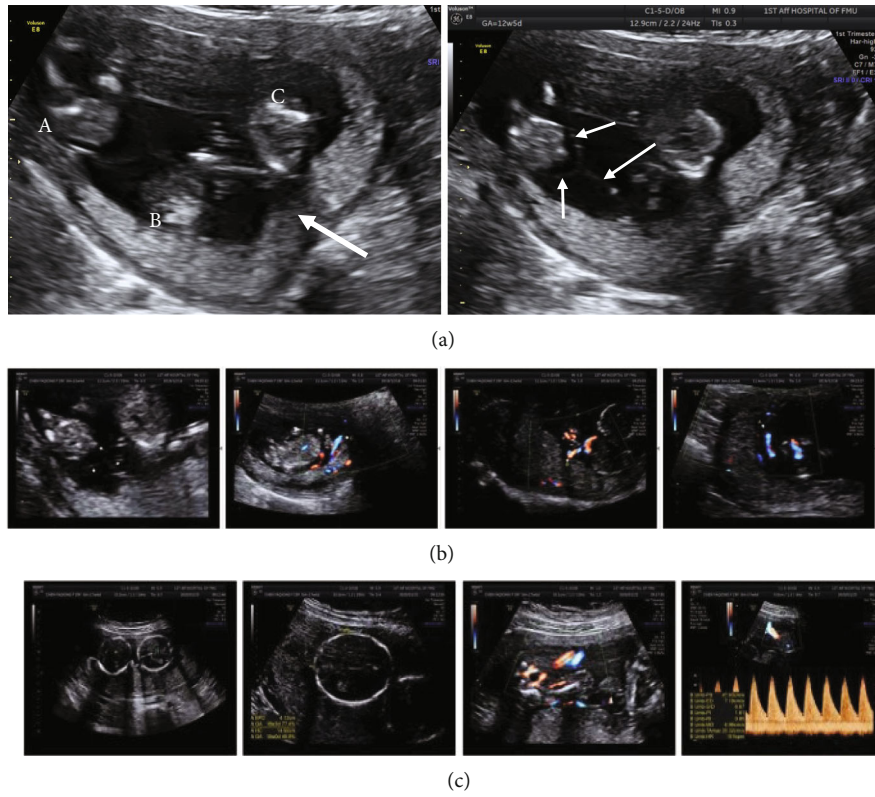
B-ultrasound monitoring results of identical triple pregnancies. (a) Left: three independent fetuses a, b, and c can be seen, and the arrow is a single placenta; right: three independent amniotic sacs are seen, and the arrow is the amniotic echo; (b) early color Doppler ultrasound NT examination; (c) ultrasonography in the second trimester (20 weeks).
